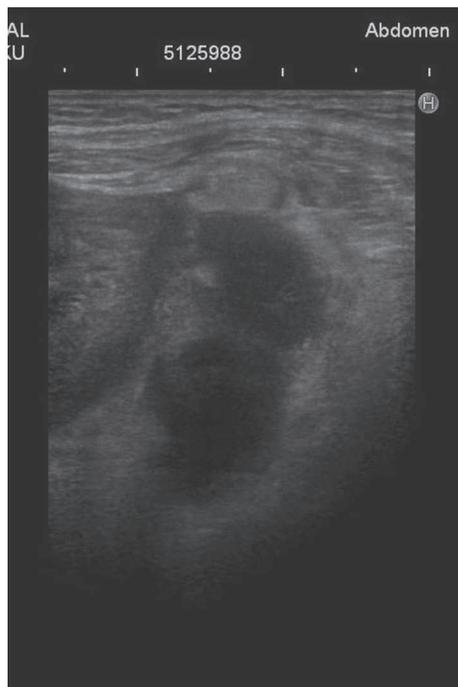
Preoperative ultrasonography. An abscess was identified in the periappendiceal area.
